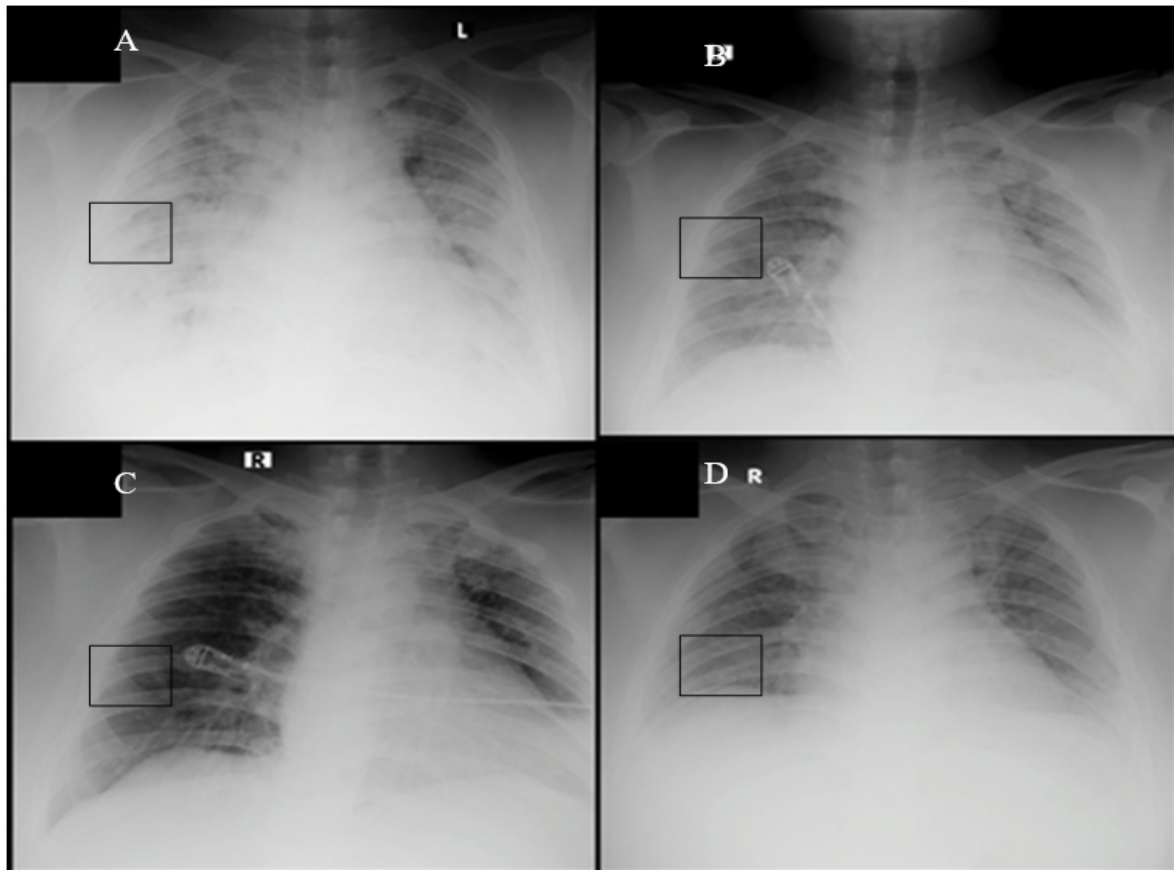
Serial Chest X-ray. (A) Chest X-ray taken on 1st day of admission (B) Chest X-ray taken on 5th day of admission (C) Chest X-ray taken on 8th day of admission (D) Chest X-ray taken on 13th day of admission.
